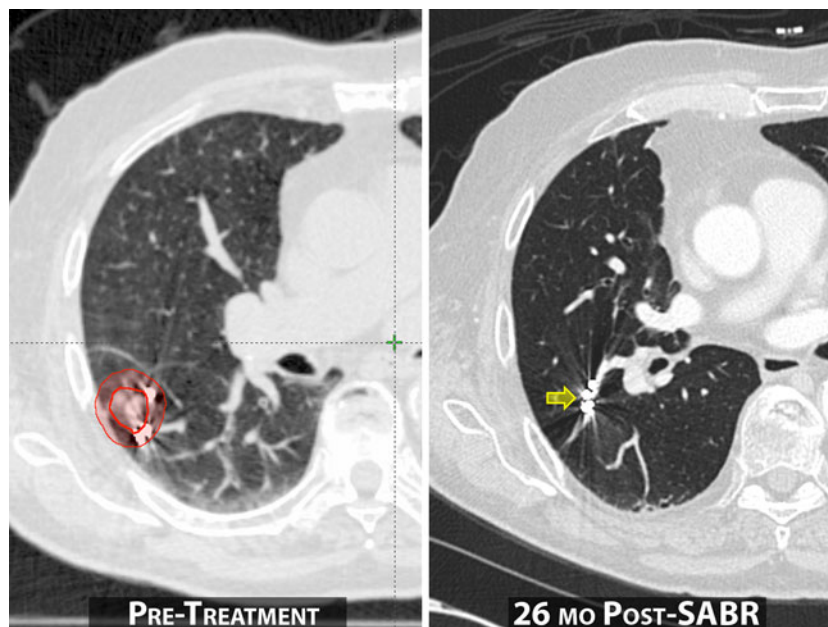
Peripherally located stage I NSCLC in a medically inoperable patient, treated with stereotactic ablative radiotherapy (SABR), using a dose of 50 Gy in four fractions. The tumor and surrounding target volume are outlined in *red*. Metallic fiducial markers implanted via CT-guided percutaneous needle placement at the time of biopsy facilitated image-guided dynamic tumor tracking with the radiation beam during treatment. There was a complete response with only minimal fibrosis surrounding the implanted markers (*arrow*), and no evidence of disease 26 months after treatment
